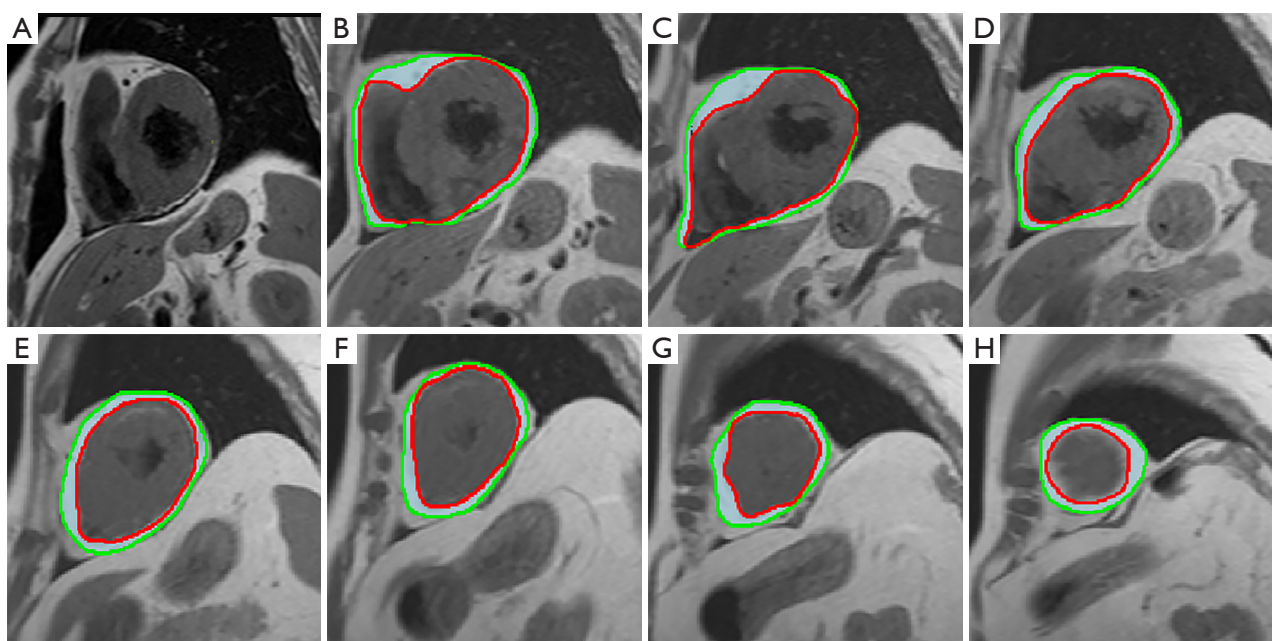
Short-axis MR slices for different levels (basal to apical). (A) Not sketch level, step by step (B-H) sketch different levels of short-axis after MRI slices. Red line: myocardial intima; green line: pericardial; light green line: EAT. MR, magnetic resonance; MRI, magnetic resonance imaging; EAT, epicardial adipose tissue.
